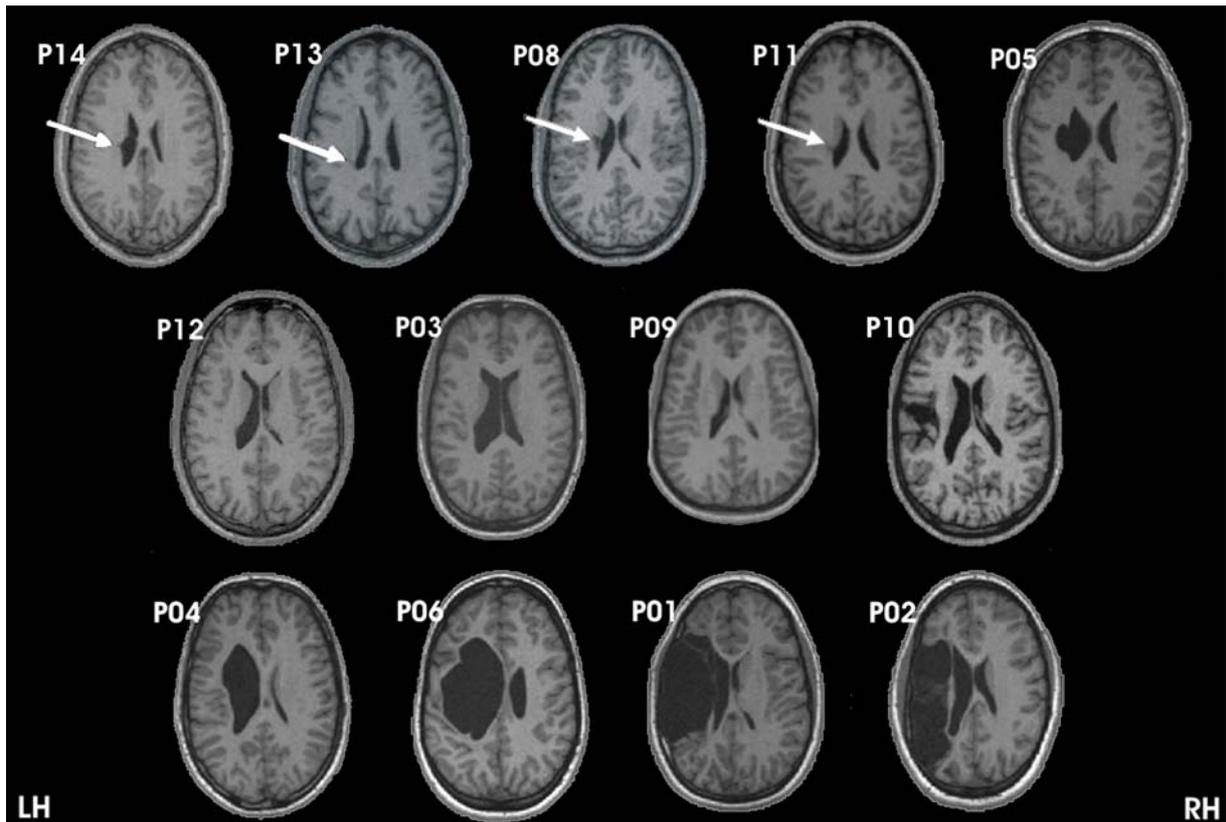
Axial slices of the T1-weighted datasets of patients. Periventricular lesions can be identified as irregular dilatations of the left lateral ventricles; arrows indicate the gliotic scars in the small lesions. Images are arranged according to lesion size (starting top left with the smallest lesion).
